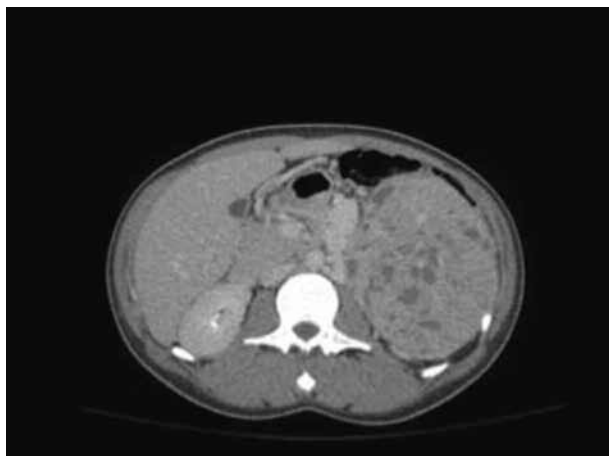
Contrast CT of the abdomen showing huge vascular mass arising from the left kidney (arrow).
